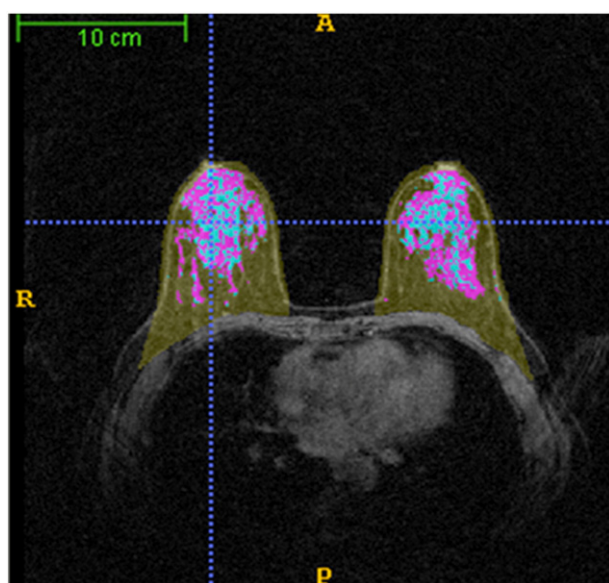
Magnetic resonance imaging analysis. The volume of interest (VOI) of breasts, yellow color for the whole breast, blue for the fibroglandular tissue without enhancement and pink for the enhanced fibroglandular tissue.
